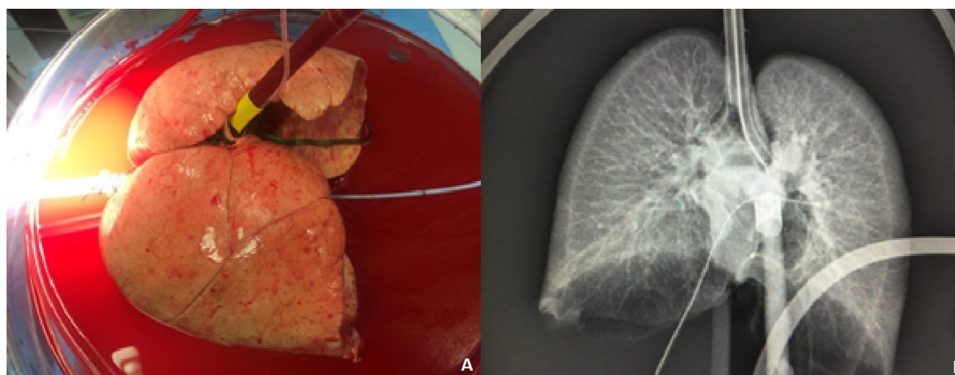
A: Lungs appearance during EVLP; B: Lungs X-ray after EVLP.
